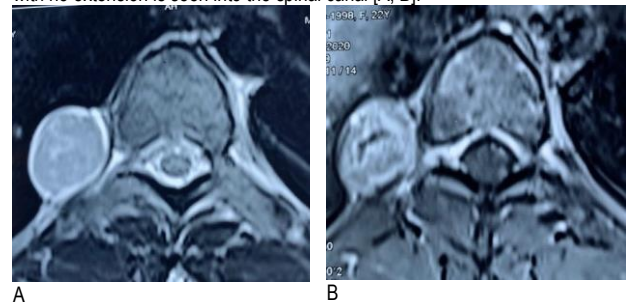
MRI of the dorsolumbar region with contrast demonstrates the lesion is hyperintense in T2WI with no marginal or intrinsic flow voids [A]; after injecting gadolinium there is heterogeneous contrast enhancement with central necrotic area [B].
